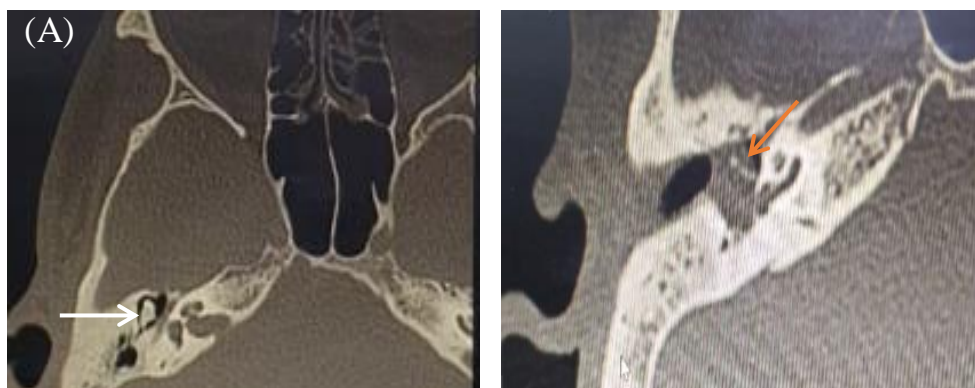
(A and B) axial CT scan images of 29 years old male with right side COM.
